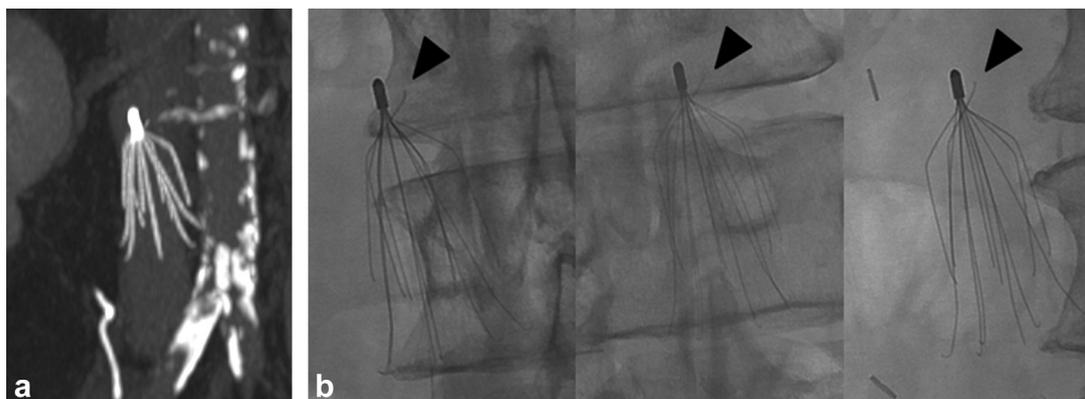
(a) Coronal CT image using maximum intensity projection shows a G2 IVC filter. No filter fracture was visualized by the 2 study readers or the body radiologist interpreting the study. (b) A frontal and 2 oblique magnification spot radiographs in the same patient after 2 weeks show a fractured filter arm (black arrowheads). Knowledge of this was important for procedure planning, as a cavogram was not performed in the presence of a free intravascular fragment for fear of dislodging it while placing the diagnostic catheter. The fractured arm was first removed using endobronchial forceps and was clearly loose in the filter based on how easily it was removed. In retrospect, the fractured arm could be visualized on the CT scan; however, it was more conspicuous on the radiographs.
